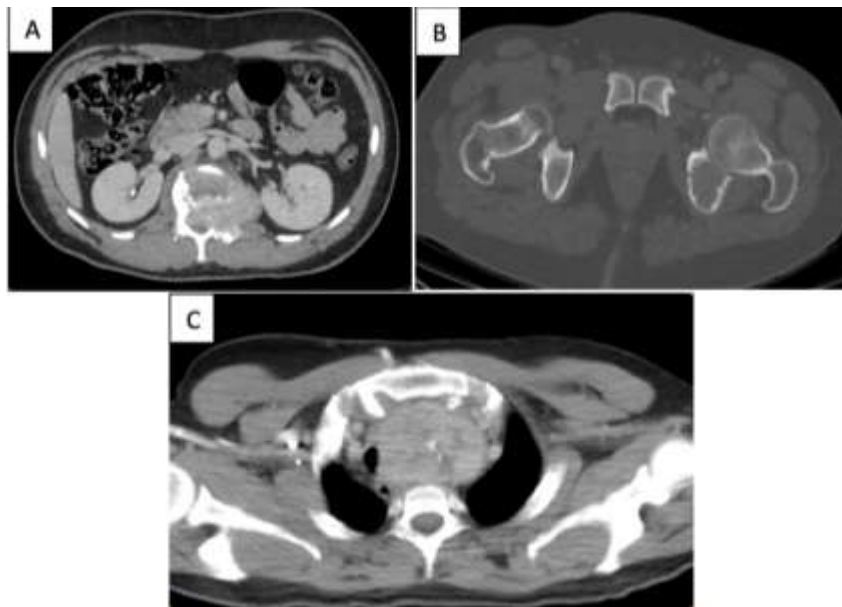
Chest abdomen and pelvic injected CT scan showing osteolytic lesions of L1 (A) with medullary canal invasion, left ischium (B), and the plunging goitre (C).
